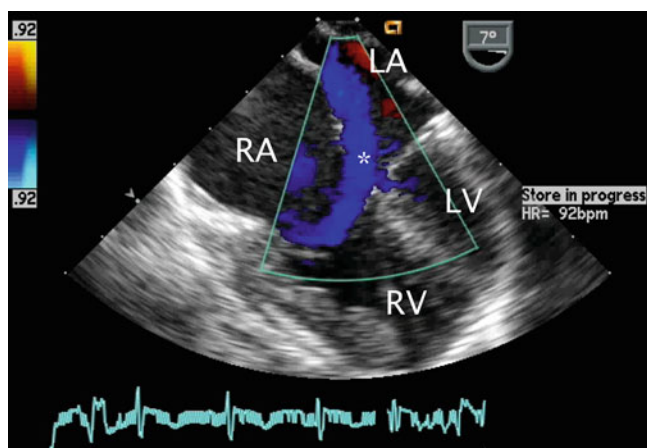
Color Doppler image displaying left-to-right shunting across a primum atrial septal defect (*asterisk*) in the mid esophageal four chamber view. LA left atrium, LV left ventricle, RA right atrium, RV right ventricle
